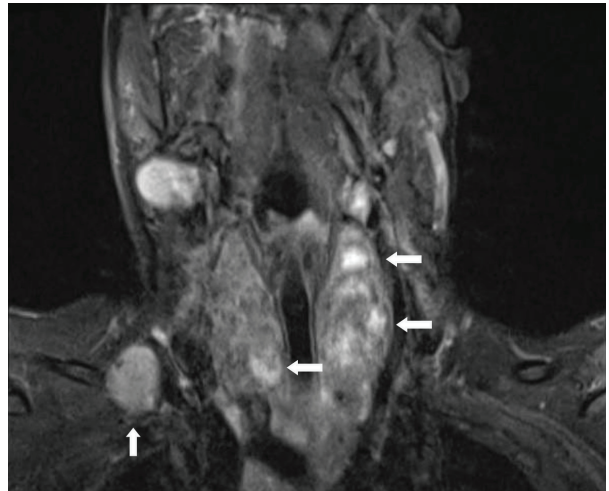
An enlarged lymph node that seems hyperintense on T2-weighted coronal image on the right supraclavicular region (vertical arrow) in addition to multiple calcified nodular lesions in both thyroid lobes (horizontal arrows)
